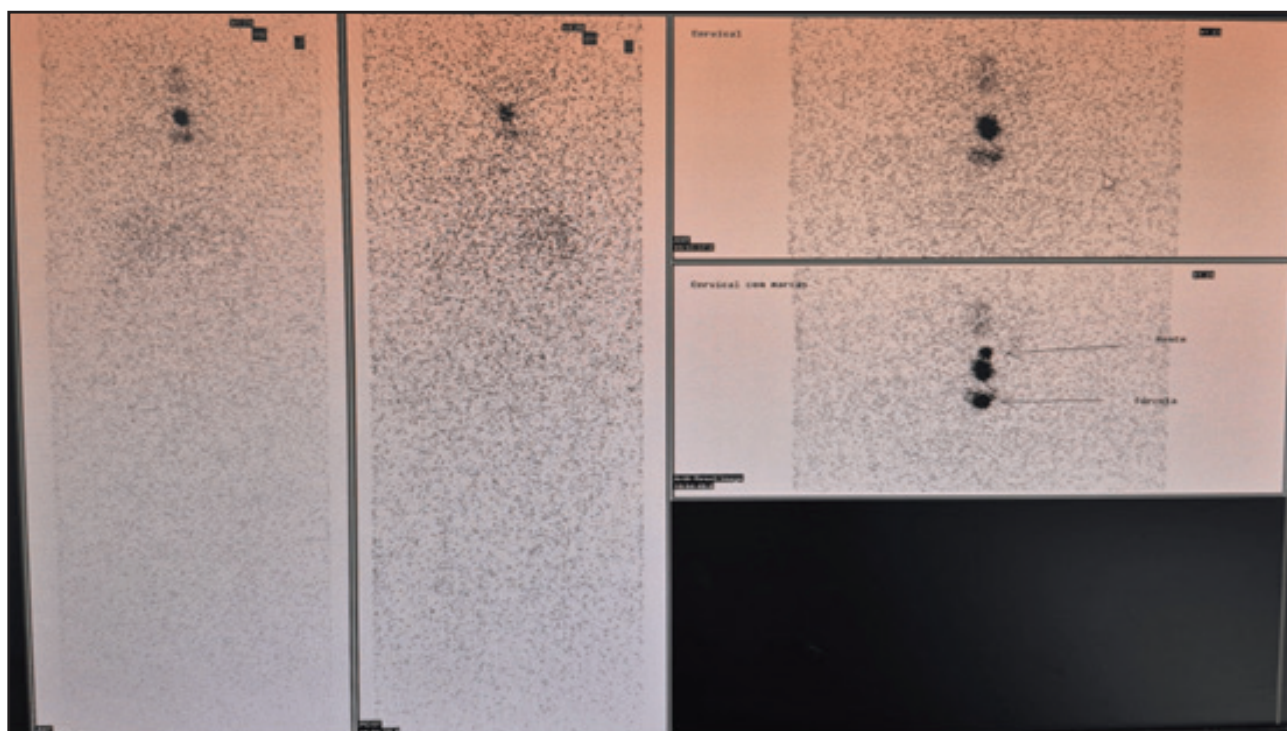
Body scintigraphy after therapy: Foci of radionuclide uptake were detected in the anterior cervical projection, consistent with residual functioning thyroid. The remaining biodistribution of the radionuclide shows no significant changes.
